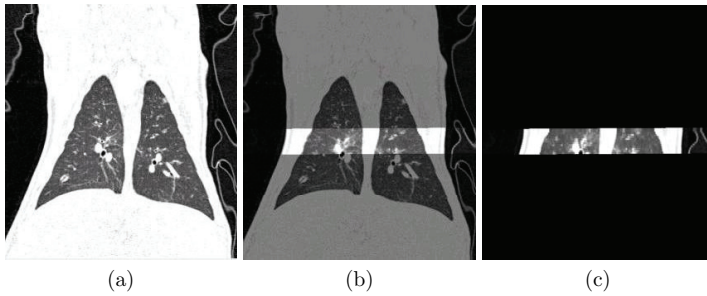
Example of the result of affine registration between Xe-CT data and dynamic respiratory-gated CT data. (a) T_0 whole-volume dynamic respiratory-gated CT data. (b) Fused image. (c) Deformed first breath of the Xe-CT data.
